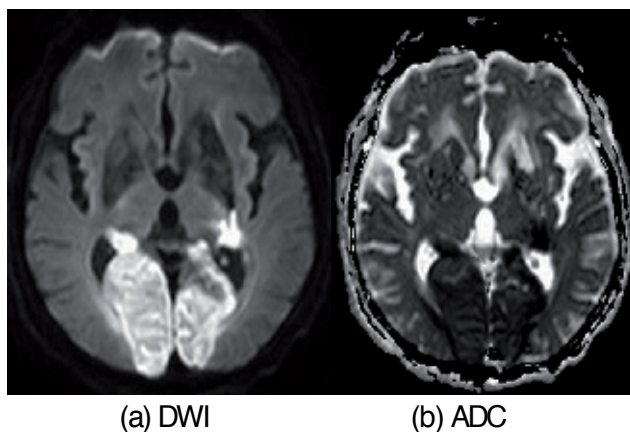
a) DWI shows hyperintense signal along bilateral posterior cerebral arterial territories. b) corresponding ADC map demonstrates hypointense signal.
